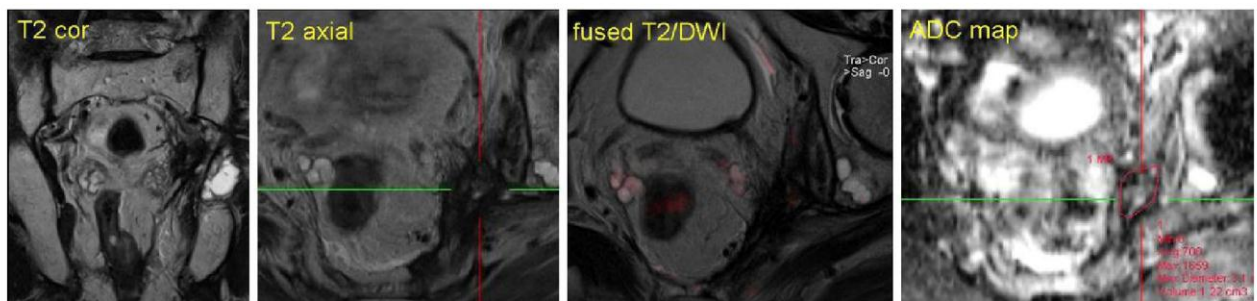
A 65-year-old patient was surgically treated for low rectal adenocarcinoma (TME) in 2010, developed recurrence disease in 2012. (pic. 2) Initial MRI scan, T2 images
